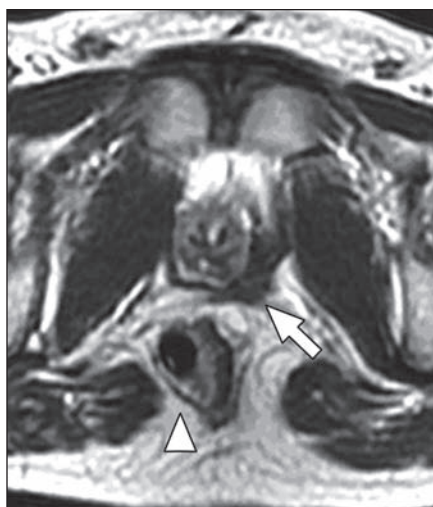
8-year-old boy with eccentric location of bowel after repair of high anorectal anomaly (rectal-bladder neck fistula). A, Axial T1-weighted MR image of pelvis shows irregular shape and asymmetry of sphincter muscle (*arrow*). Rectum has eccentric location (*arrowhead*) to left side of sphincter. B, Coronal T2-weighted MR image of pelvis and lower abdomen shows poorly developed irregular and asymmetric muscles (*arrow*) and eccentric location (*arrowhead*) of rectum.
